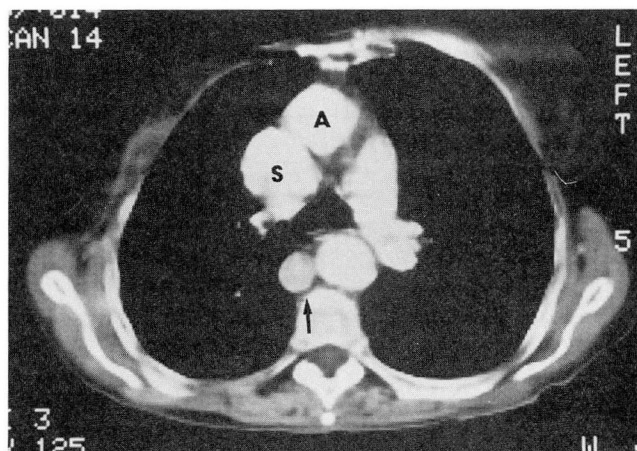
Contrast-enhanced CT scan at the level of the aorto-pulmonary window showing prominent azygous vein (arrow). Superior vena cava (S), ascending aorta (A), and main pulmonary artery are all in normal position.
